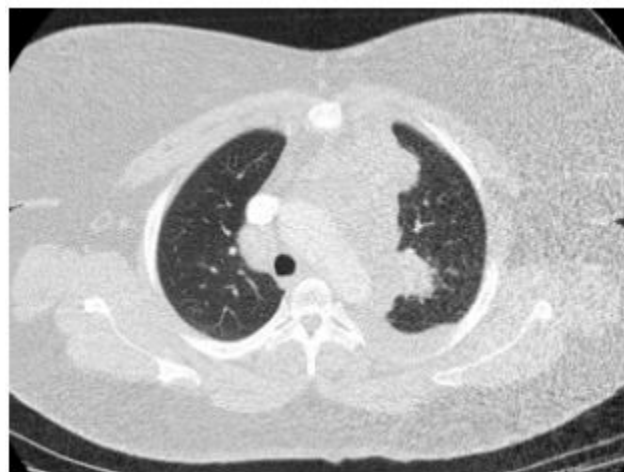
CT scan of solid mass in superior mediastinum with mediastinal and hilar lymphadenopathy.
